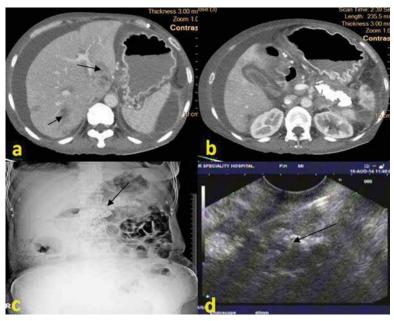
(a, b): CT scan abdomen showing multiple, ill-defined, heterogeneous moderately peripherally enhancing lesion of varying sizes noted in both lobes of liver largest of size 1.9 x 1.5 cm noted involving segment IV, (c):X ray abdomen showing extensive pancreatic calcification, (d): Endoscopic ultrasound showing multiple parenchymal calcific foci in pancreas (black arrow) and single, heterogeneous hypoechoic mass of size 39.2x36.4 mm, seen near tail of pancreas; EUS FNA done (white arrow)
